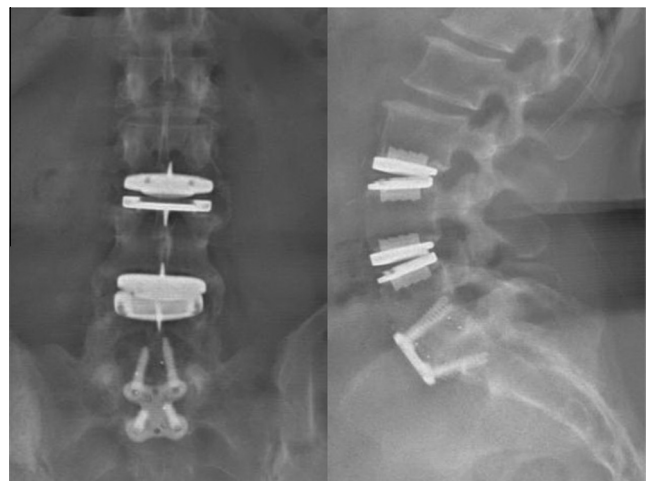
(Left) Anteroposterior and (right) lateral radiographs showing hybrid fusion with a combination of anterior lumbar interbody fusion and total disc replacement.
